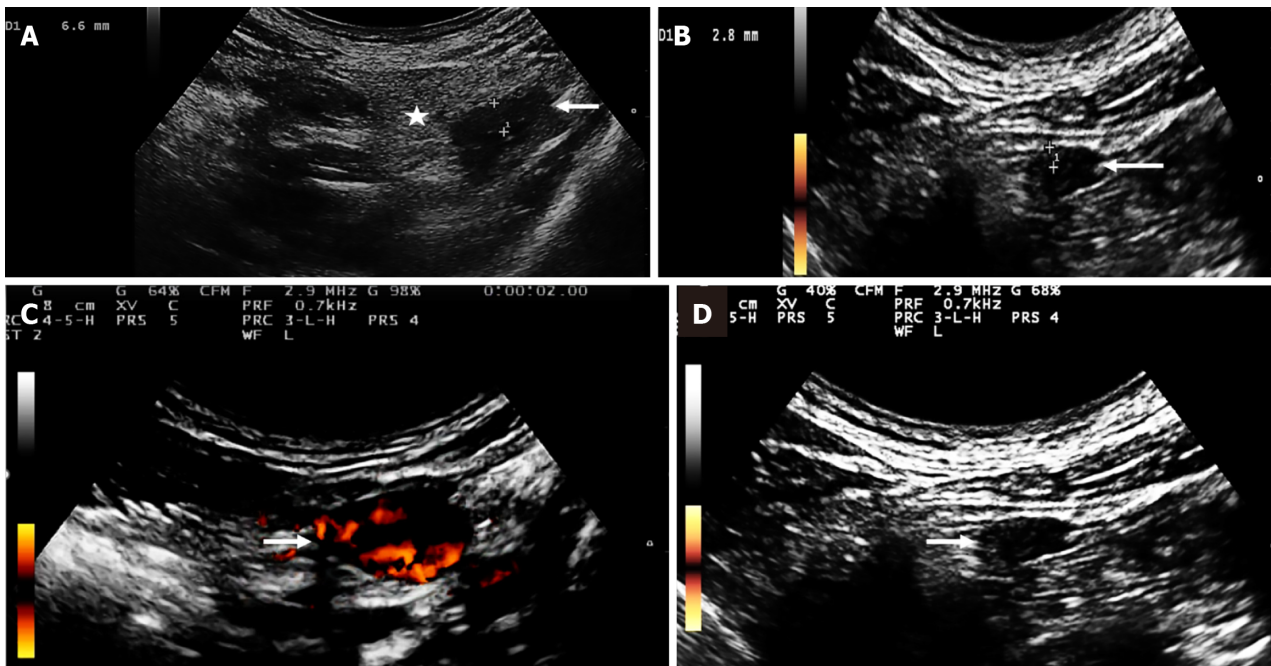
Monitoring intestinal inflammatory activity: Improvement after adalimumab treatment. A and B: Reduced intestinal wall thickening (arrows) and perienteric fat (star) (short axis images of the sigmoid colon); C and D: Decreased Doppler signal per the Limberg scale (arrows).
